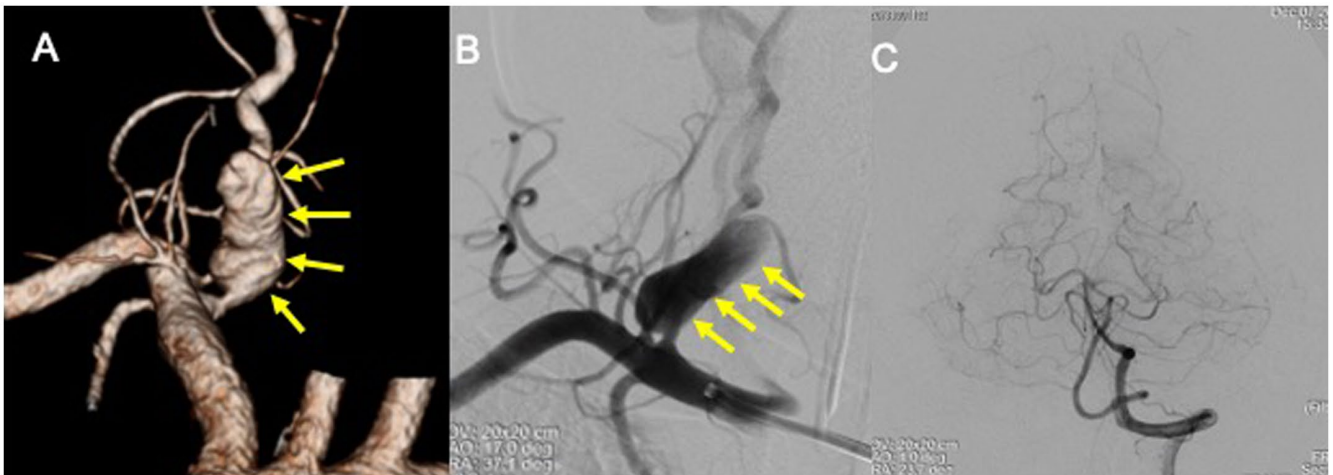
(A) Three-dimensional computed tomography angiography showed a 40 mm diameter fusiform aneurysm from the proximal right vertebral artery(yellow arrows). (B) Antero-posterior view on right vertebral artery angiography showed a gourd-shaped aneurysm at the V1 segment of vertebral artery (yellow arrows). (C) Antero-posterior view on left vertebral artery angiography showing elongation of intracranial vertebral and basilar artery.
